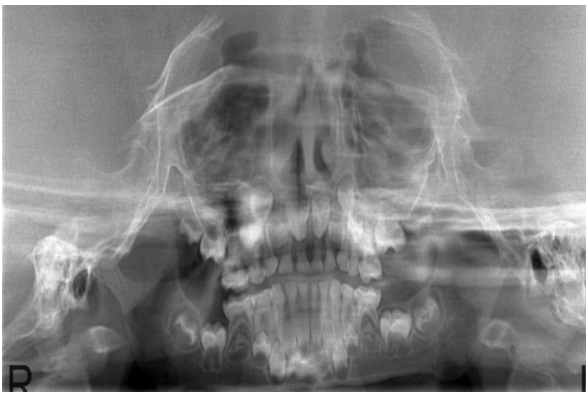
Panoramic X-Ray of the patient.
